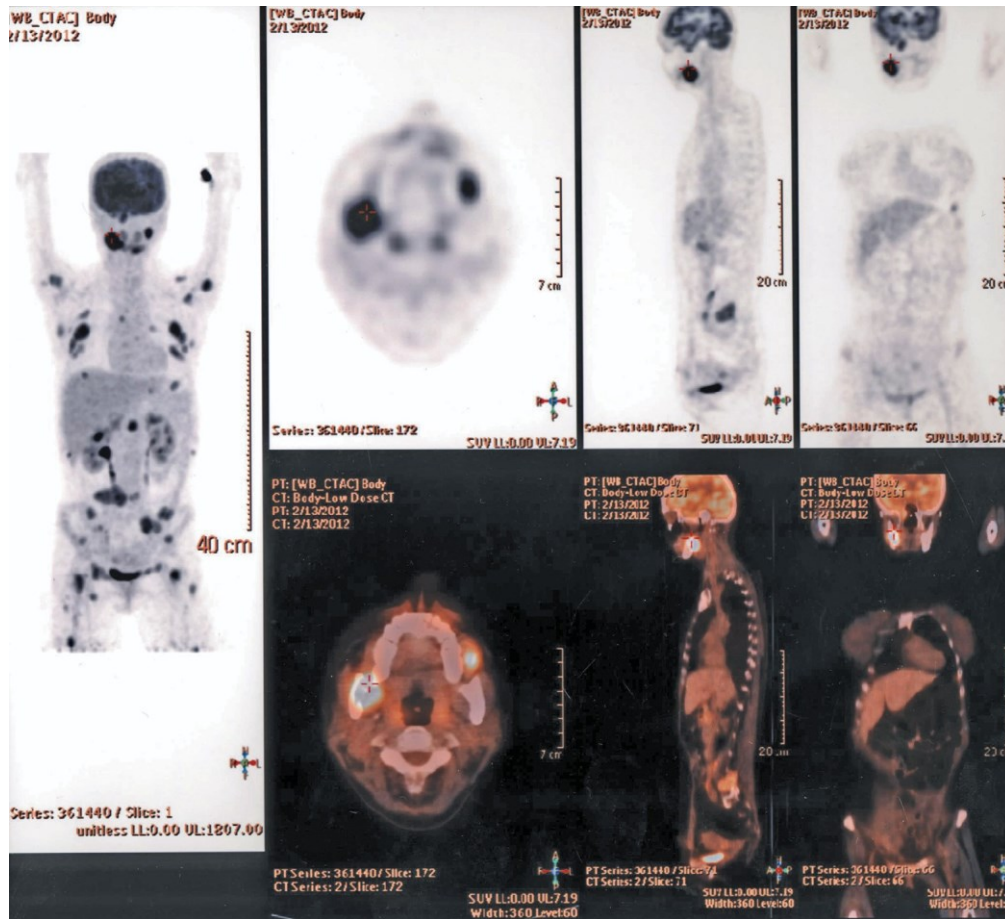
PET/CT with intense pathological accumulation of fluorodeoxyglucose (FDG) in multiple regions of the skeleton.
